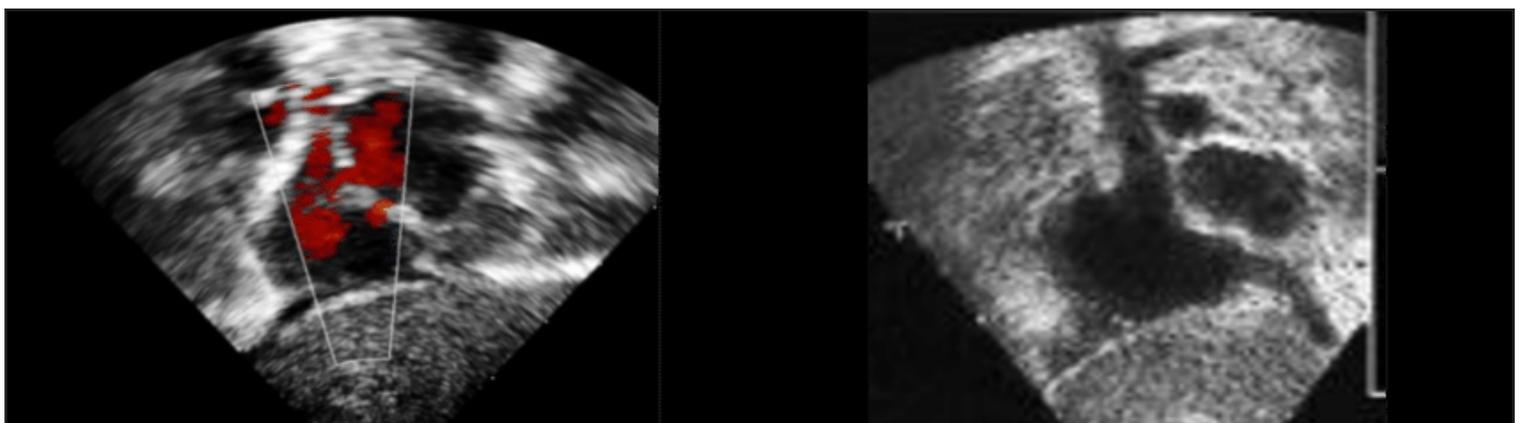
Apical 4 chamber view. No abnormality detected.
